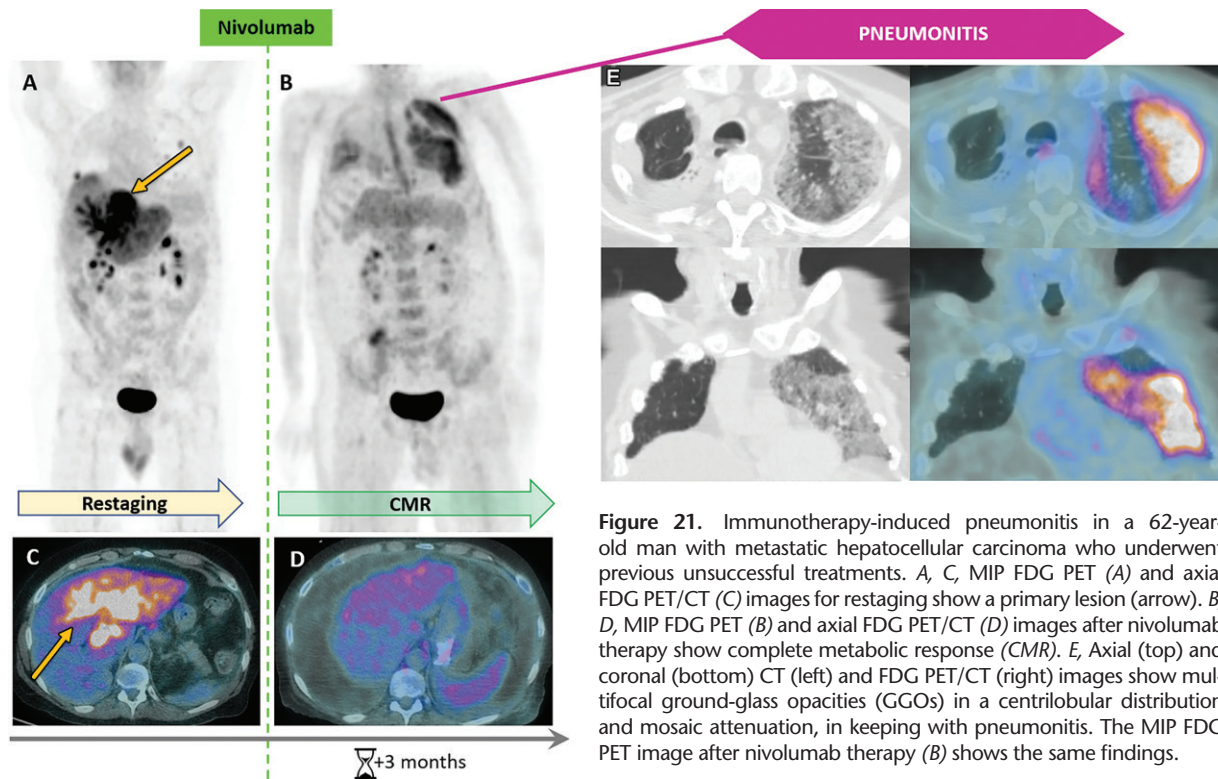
Immunotherapy-induced pneumonitis in a 62-year-old man with metastatic hepatocellular carcinoma who underwent previous unsuccessful treatments. *A*, *C*, MIP FDG PET (*A*) and axial FDG PET/CT (*C*) images for restaging show a primary lesion (arrow). *B*, *D*, MIP FDG PET (*B*) and axial FDG PET/CT (*D*) images after nivolumab therapy show complete metabolic response (CMR). *E*, Axial (top) and coronal (bottom) CT (left) and FDG PET/CT (right) images show multifocal ground-glass opacities (GGOs) in a centrilobular distribution and mosaic attenuation, in keeping with pneumonitis. The MIP FDG PET image after nivolumab therapy (*B*) shows the same findings.
